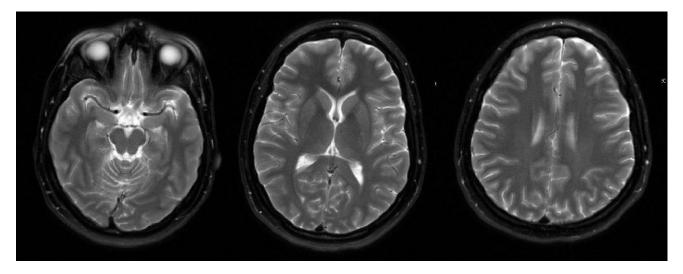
MRI Brain shows normal findings
